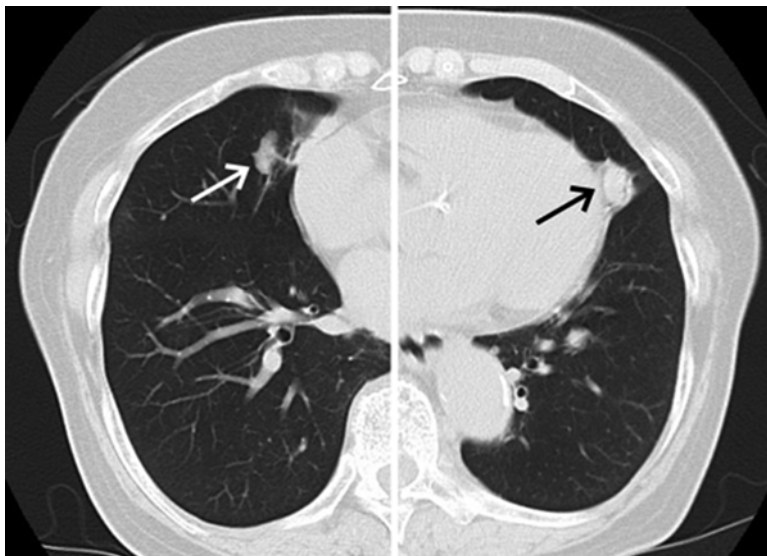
December 2013 chest CT scan showing that the pulmonary metastases had slightly increased in size
